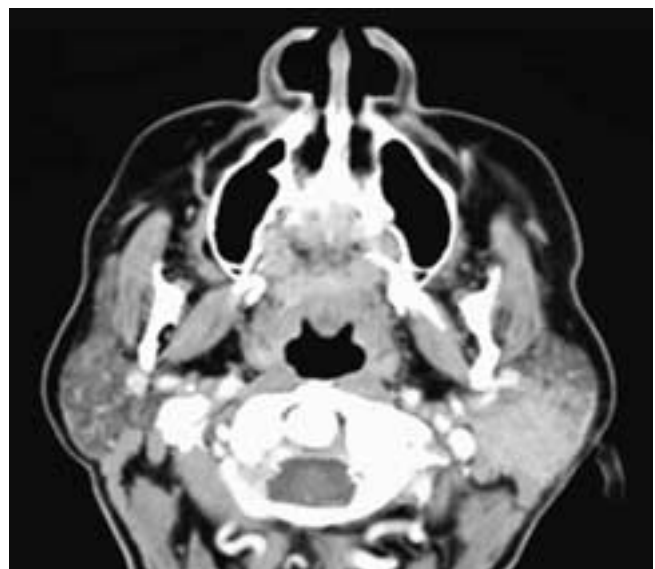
Axial CT scan shows an irregularly margined, infiltrative mass in the left parotid gland. The tumor has started to extend beyond the parotid gland capsule. This patient had an SCC.
